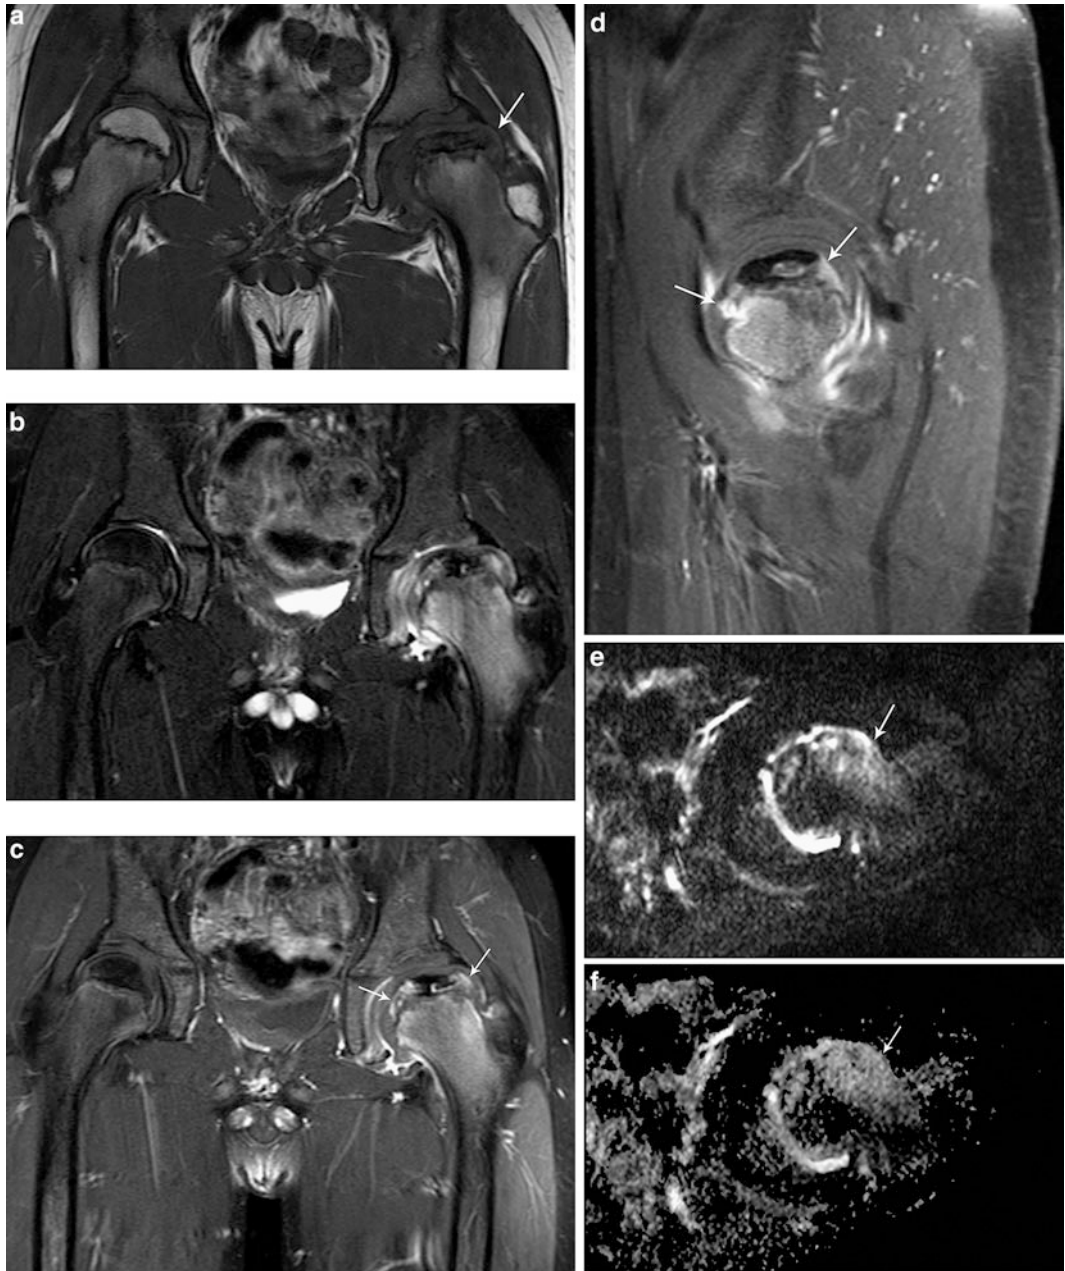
Ten-year-old boy with left LCP disease. (a) Coronal T1-weighted image of the pelvis shows collapse of the capital epiphysis with central necrosis and lateral extrusion of the femoral head (*arrow*). The right hip is normal. (b) Coronal water-sensitive image demonstrates bone marrow edema within the proximal left femur with central necrosis and joint effusion. (c, d) Coronal and sagittal T1-weighted
